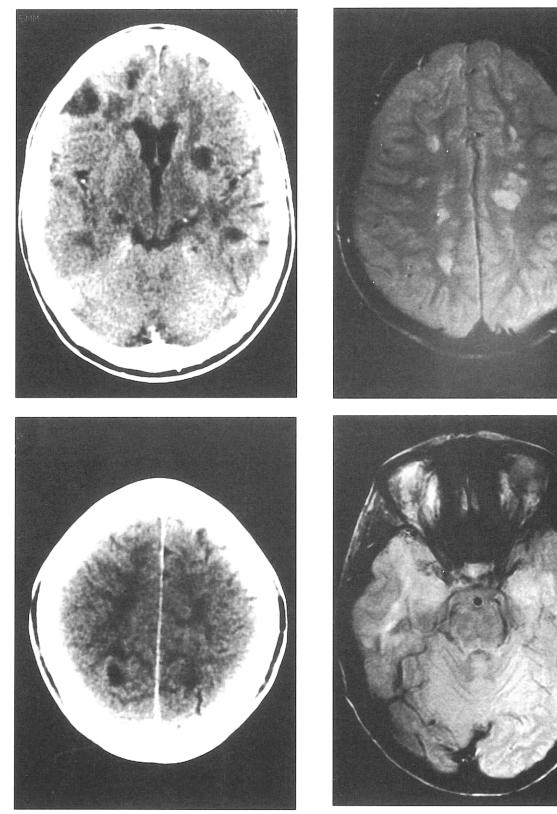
(a) and (b) show CT scans with focal subcortical lesions extending into the gray matter in patient 02 (FH), who has an 'aggressive' MS.
